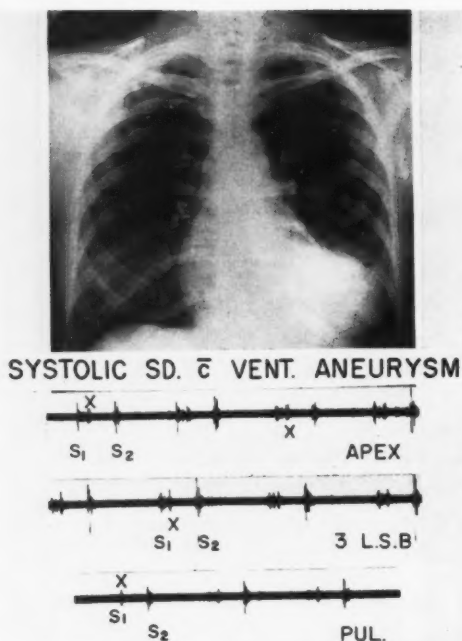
A 50-year-old woman with aneurysm of the left ventricle resulting from a previous myocardial infarction. Note aneurysm shown on the x-ray which produced an early systolic sound (X) as shown on phonocardiograms. The sound coincided with a prominent localized systolic impulse palpated at the apex.
